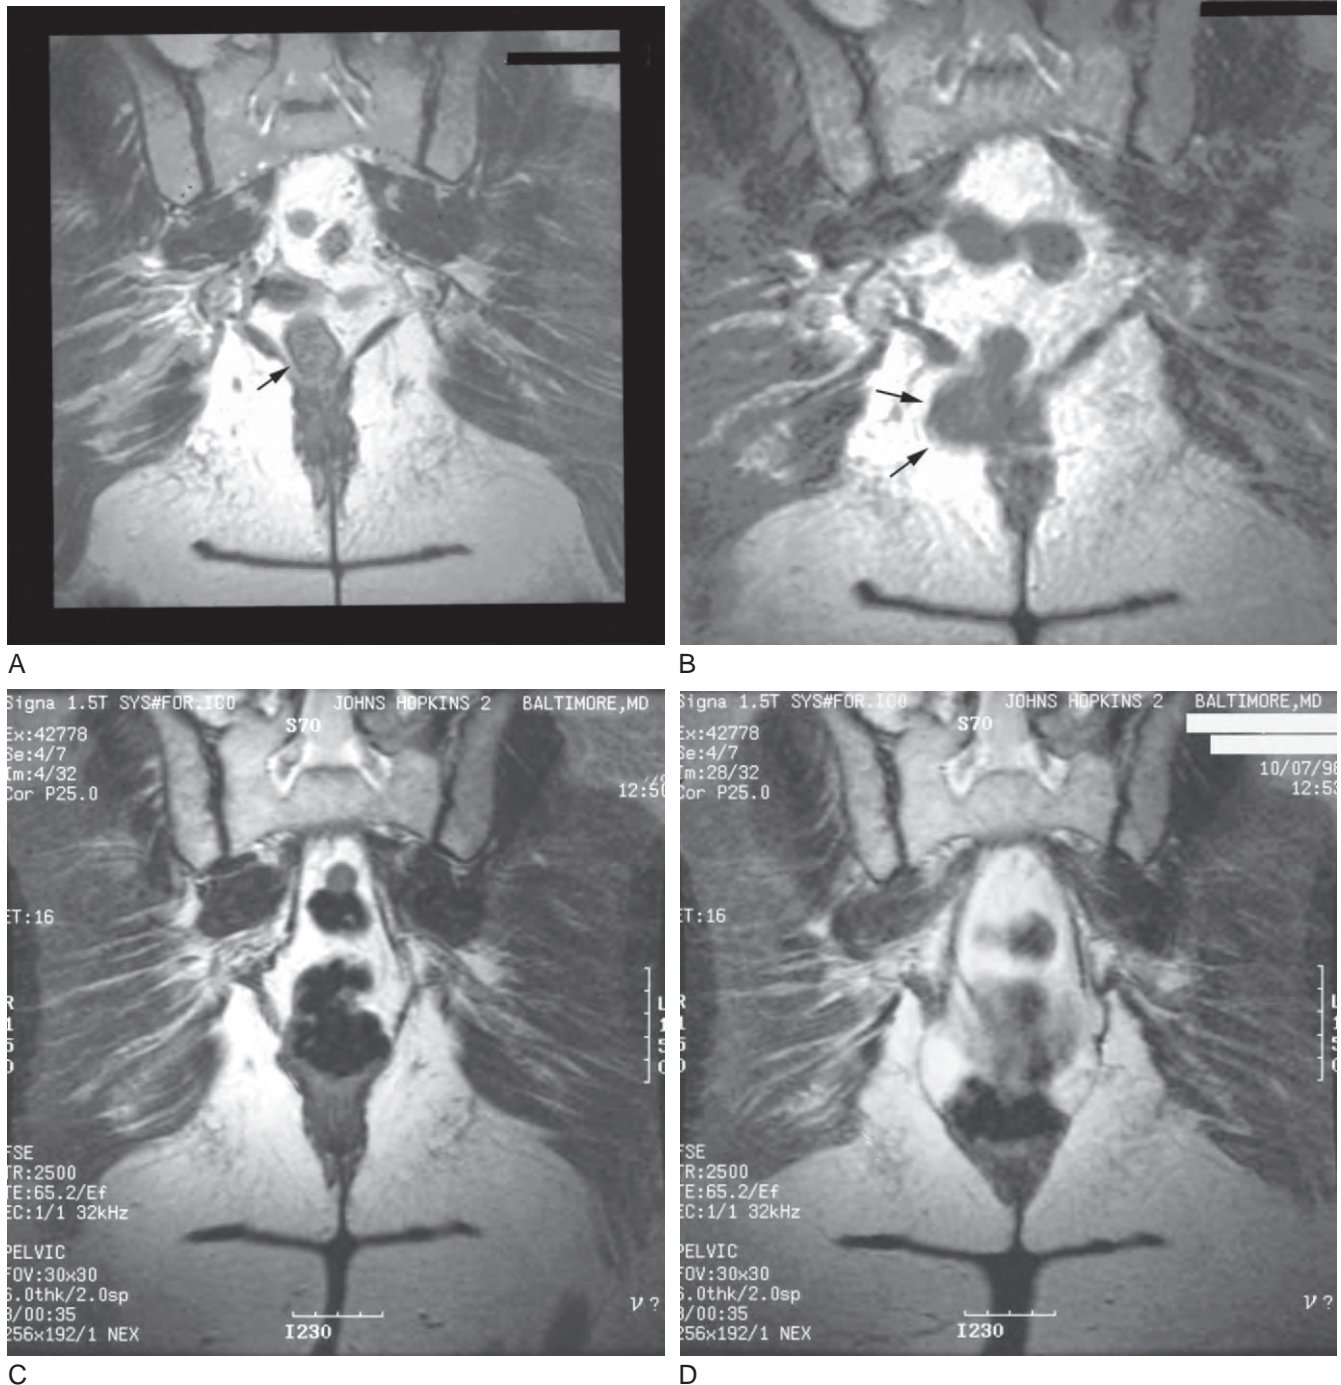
Coronal T2-weighted magnetic resonance images. A, Rest image showing a midline rectum (*arrow*) in patient with obstructed defecation. B, Strain image demonstrating the rectum (*arrows*) herniating through a defect in the right levator ani complex. C, Postoperative rest image after a combined abdominoperineal approach to simple levator hernia repair with no absorbable sutures. D, The rectum remains midline after hernia repair, and the patient's symptoms of obstructed defecation were resolved. (From Kaufman HS, Buller JL, Thompson JR, et al: Dynamic pelvic MR imaging and cystocolpoproctography alter surgical management of pelvic floor disorders. *Dis Colon Rectum* 44:1575, discussion 1584, 2001.)
